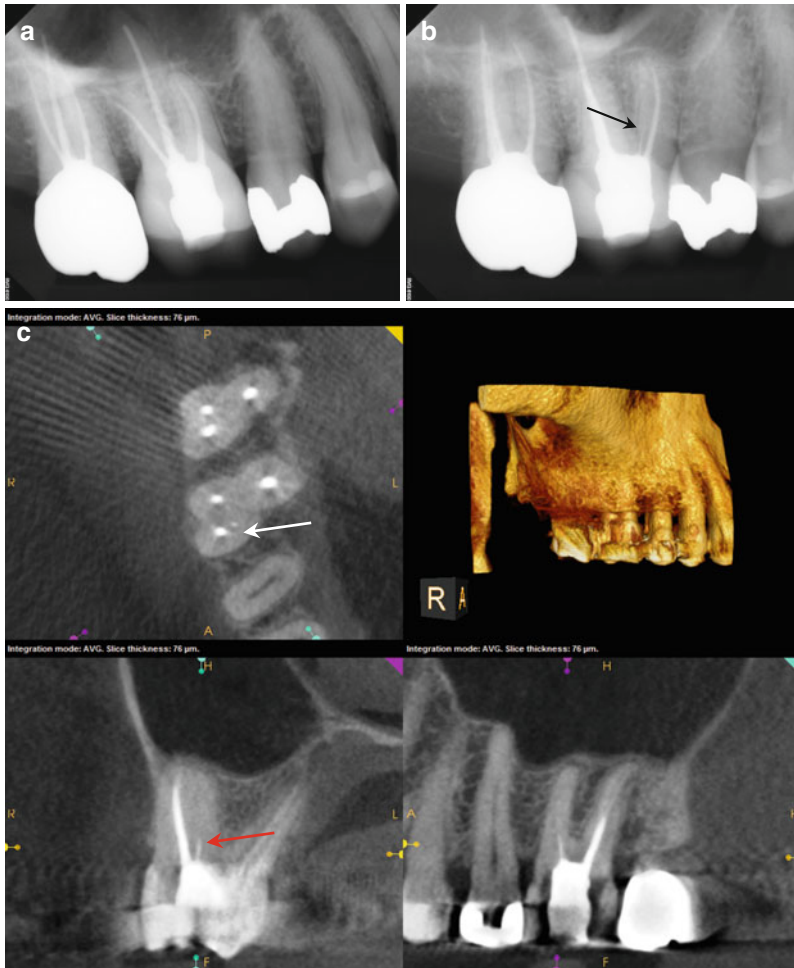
(a, b) Preoperative radiographs disclose no obvious periapical pathology, but the obturation of the MB root in #3 appears to be off-center, and a thin radiopaque line is evident slightly distal to the filled MB canal (*black arrow*). (c) The axial section of #3 reveals a small high-density dot palatal to the MB₁ canal (The *white arrow* points to a sealer tract from the previous root canal filling in the MB root). The location, as well as the configuration relative to the MB₁ (*red arrow*), is suggestive of a sealer tract in the uninstrumented MB₂ canal. (d) The colorized 3-D coronal section highlights the presence of the sealer in MB₂, with a similar density to the root canal filling material (*yellow arrow*). (e) The axial section of #2 demonstrates a broad fusion of the MB and Palatal roots (*white arrow*), while the coronal section reveals a low-density line that is suggestive of MB₂ (*red arrow*). (f) The colorized 3-D axial section discloses the sealer tract in #3 and an area of dentin density in the MB root of #2 that may contain the MB₂ canal (*yellow arrows*)
